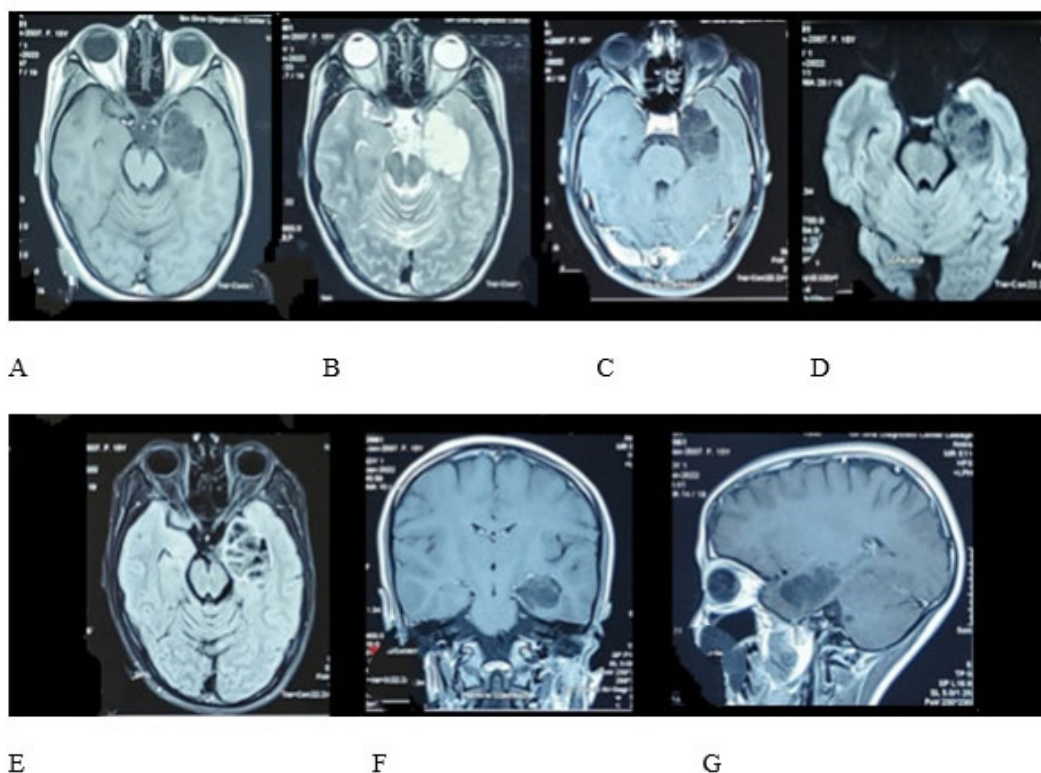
A) MRI axial T1 weighted image showing hypointense well circumscribed lesion occupying the medial part of left temporal lobe adjacent to the pole with mild compression of the ipsilateral crus of mid brain. (B) Axial T2 weighted image showing hyperintense lesion with intralesional multiple septations. (C) Axial contrast-enhanced T1 weighted image showing no enhancement of the lesion. (D) Axial diffusion weighted image showing no restriction of diffusion. (E) Axial fluid attenuated inversion recovery (FLAIR) image showing no perilesional edema. (F) Coronal contrast-enhanced T1 weighted image showing no enhancement of the lesion. (G) Sagittal contrast-enhanced T1 weighted image showing no enhancement of the lesion.
